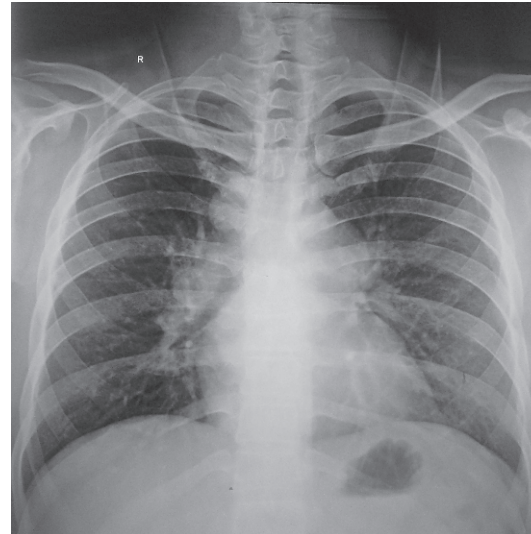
Chest X-ray PA View showing prominent hilar shadow with presence of bulge in the right suprahilar location
